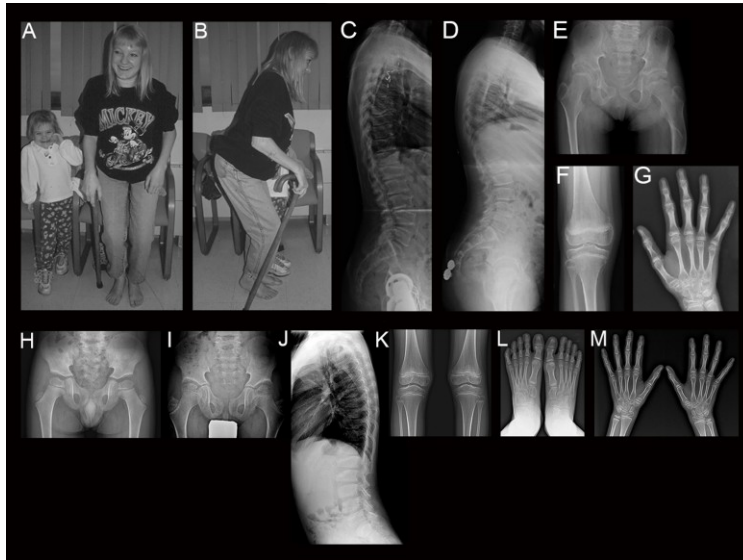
Clinical features of patients. a-c: Proband of Family 1 at 23 years. Note marked joint contractures resulting in Z posture. c: Lateral spine radiograph shows platyspondyly and irregular degenerative changes. d-g: Radiographs of the daughter of the proband of Family 1 at 12 years. d: Mild anterior wedging and platyspondyly of lateral spine. e: Hip and pelvic features include flattened and irregular femoral heads, short femoral necks, and deformed shaft of the left femur secondary to prior trauma. f: Knee radiograph shows joint space narrowing and metaphyseal irregularity. g: Note metaphyseal prominence and joint space narrowing at distal radius and distal ulna. h-m: Radiographs of the proband of Family 2 at 4 years (h) and 8 years (i-m). h: Note irregularity and mild flattening at articular surfaces of capital femoral epiphyses. Acetabulum is flat, and femoral necks are broad with mild coxa valga. i: Capital femoral epiphyses show mild flattening and dysplastic trabeculation. Femoral necks are broad and elongated with further coxa valga. Iliac are somewhat narrowed and elongated. The
